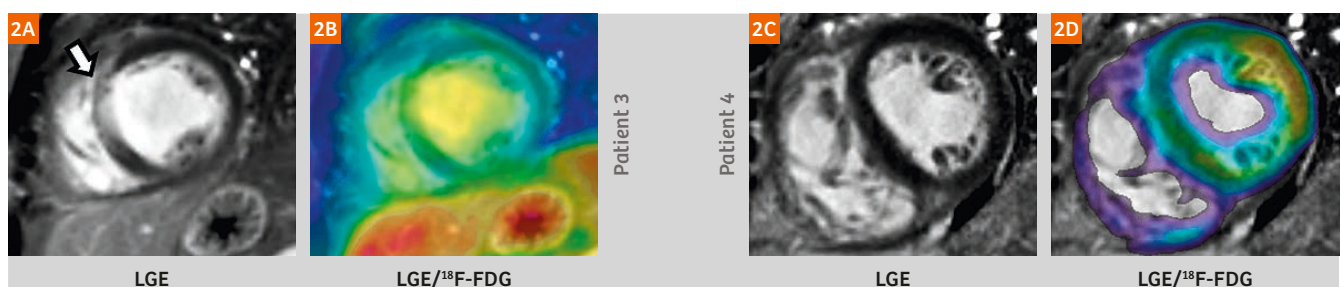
(2A, B) Patient 3 (50-year-old female), short-axis LGE MR showed transmural LGE on the anteroseptum, while fused PET/MR images demonstrated absence of high ^{18}F -FDG uptake on the same region. (2C, D) Patient 4 (42-year-old male) LGE MR showed absence of LGE on the myocardial wall. Fused PET/MR images indicated diffused intense ^{18}F -FDG uptake.
